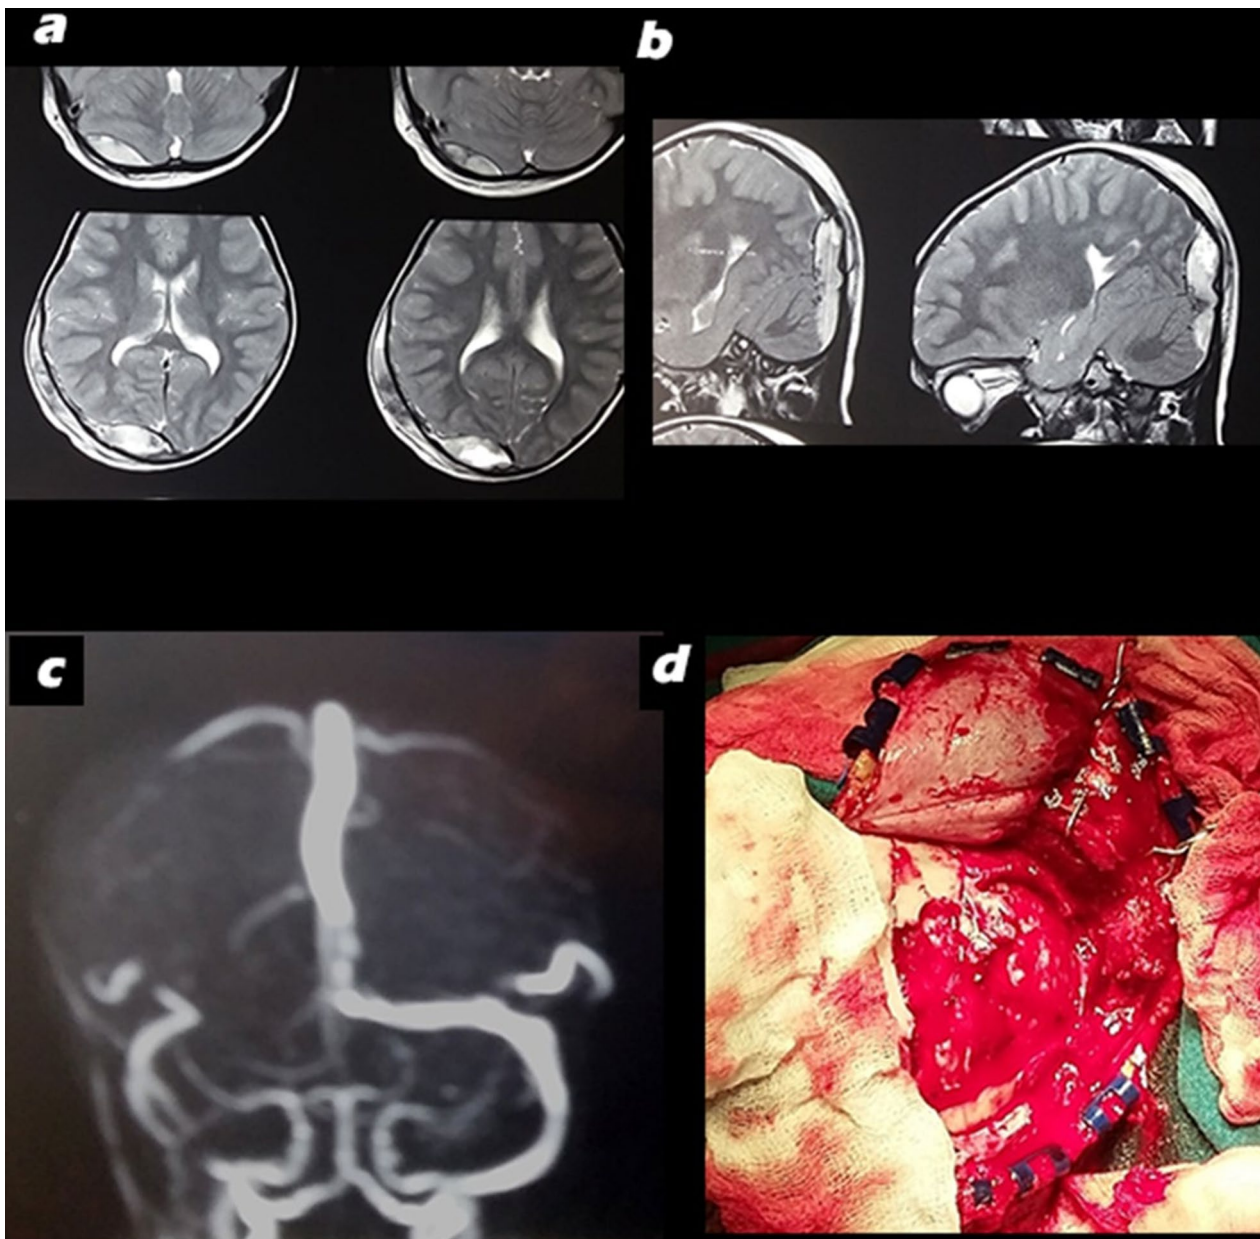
a MRI showing EDH compressing lower end of superior sagittal sinus; b sagittal MRI showing EDH centering transverse sinus; c MR venogram showing nonvisualization of right transverse sinus; d bleeding from the region of transverse sinus controlled with Gelfoam
